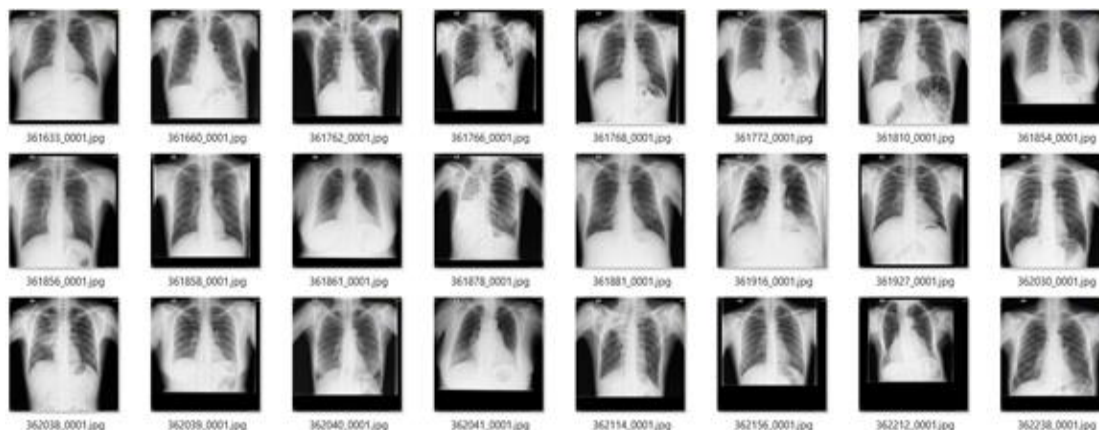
Sample chest X-ray images before preprocessing.
